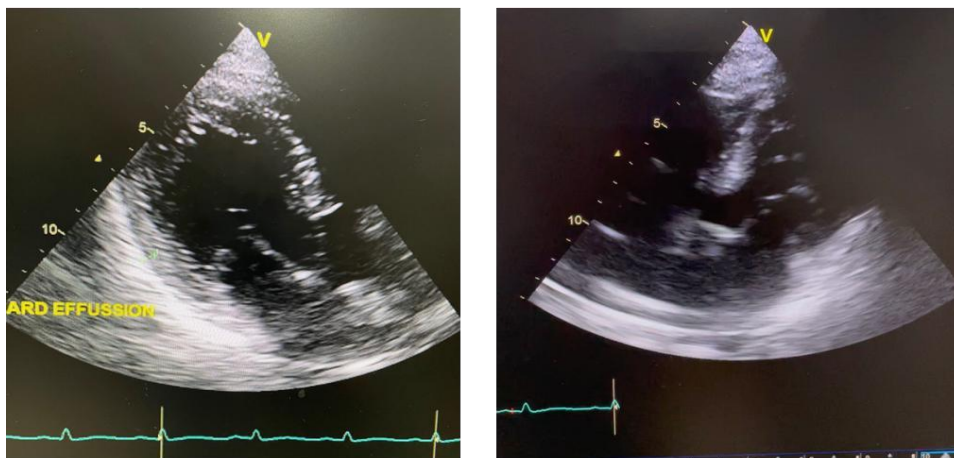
Echocardiography showed minimal pericardial effusion
